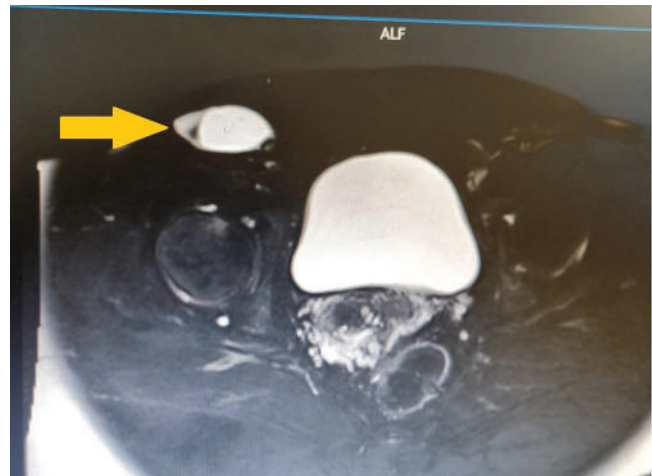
MRI image. Marked area femoral Nuck canal cyst.
